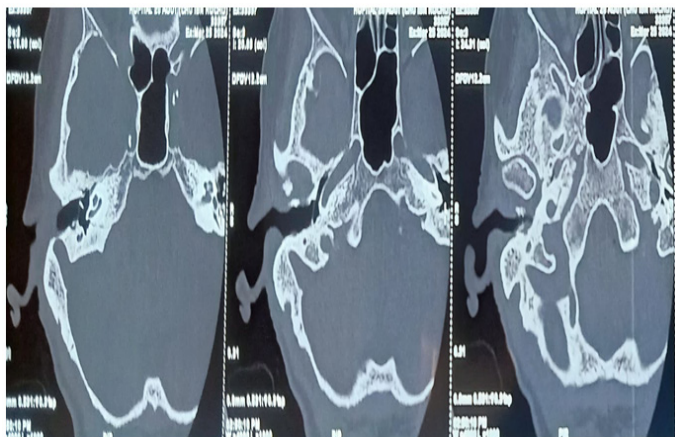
CT scan of the temporal bone showing erosion of bone in the anterior and posterior wall of the right external ear canal.
